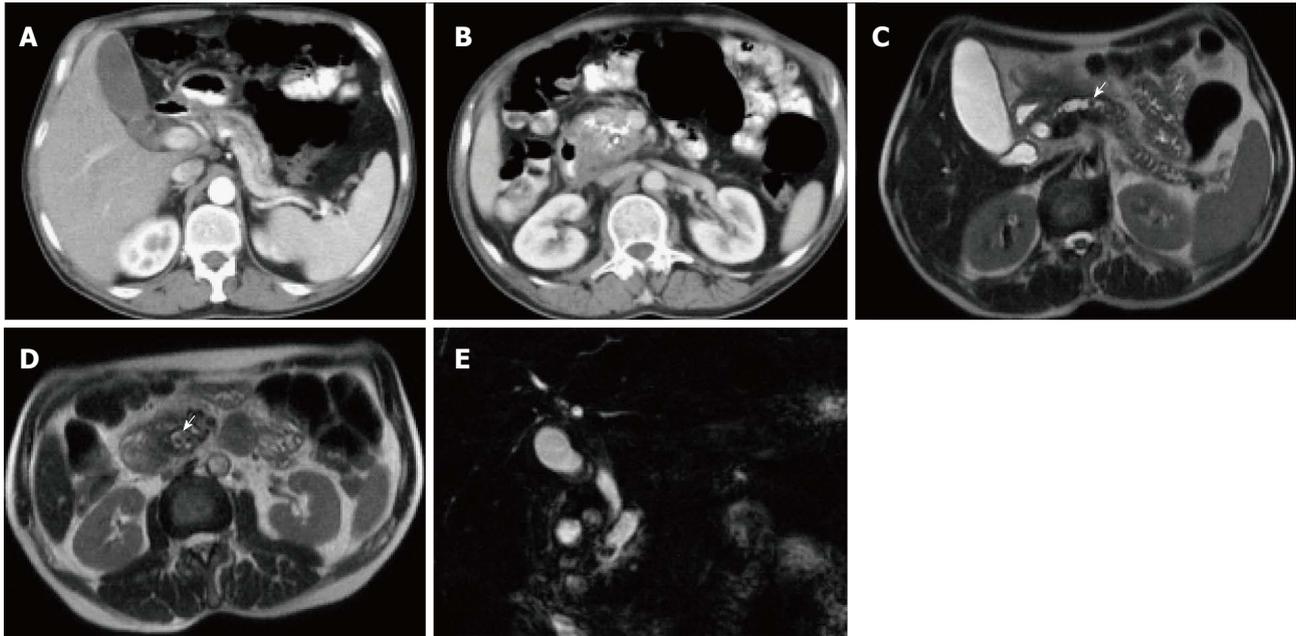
Chronic pancreatitis with pancreatic parenchymal calcifications and pancreatic duct stones. A, B: Axial CT scan during the late arterial phase; C, D: Axial T2 single-shot fast spin-echo images; E: Coronal 3D-Cholangiopancreatogram (MRCP) image. CT shows a markedly dilated and tortuous main pancreatic duct (MPD) (A, B), with foci of thick calcification involving the pancreatic head and uncinate process parenchyma (B). Large the proximal MPD stone was suspected on CT (arrow, B). MRCP shows gross pancreatic ductal dilatation with confirmation of the distal intraductal calculus (arrow, D), and shows an additional mid-pancreatic duct stone, not clearly seen on CT (arrow, C). No pancreatic masses or ductal anomalies are identified.
